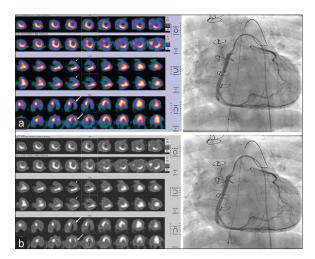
(a) Post–stress-gated SPECT images showed a fixed perfusion defect involving entire anterior segment (small arrow) and reversible perfusion defect in lateral segment (bold arrow) indicating a large LAD territory infarct with moderate reversible ischemia in lateral segment of left ventricle. (b) Coronary angiogram confirmed left main coronary artery ostial occlusion, with retrograde collateral supply from dilated right coronary artery
